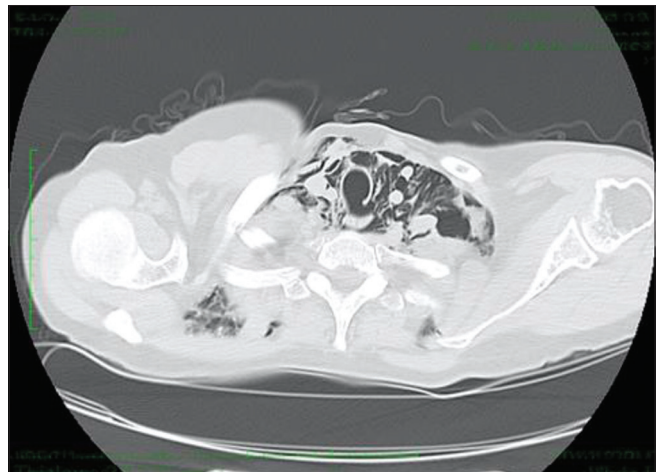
Initial chest CT depicts a large tear – gap in the posterior tracheal wall, with concomitant mediastinal and subcutaneous emphysema
